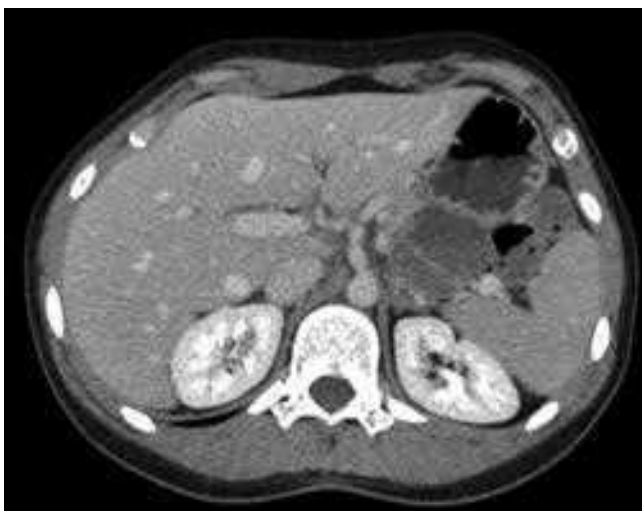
Abdominal computed tomographic scan of a 25-year-old woman demonstrating a well-circumscribed cystic lesion with septation in body/tail of pancreas. At surgery, the tumor was adherent to the splenic artery. Pathologic diagnosis was solid-pseudopapillary carcinoma.
